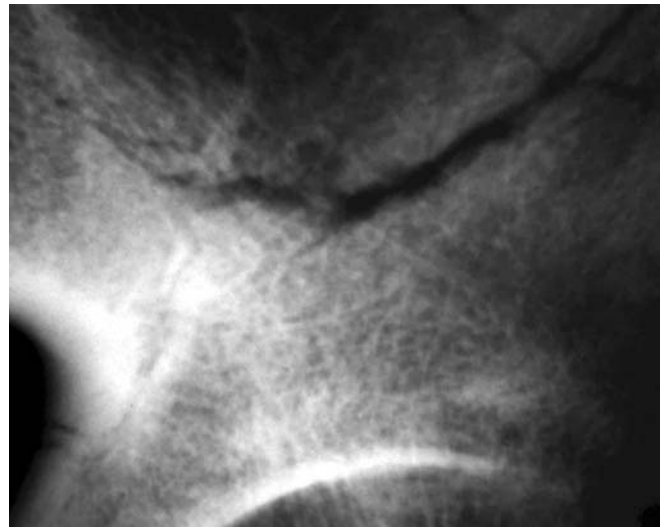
Unelaborated radiographic image of the supracetabular portion of the Neandertal hip bone from Kebara 2, Israel (~60 000 years)
